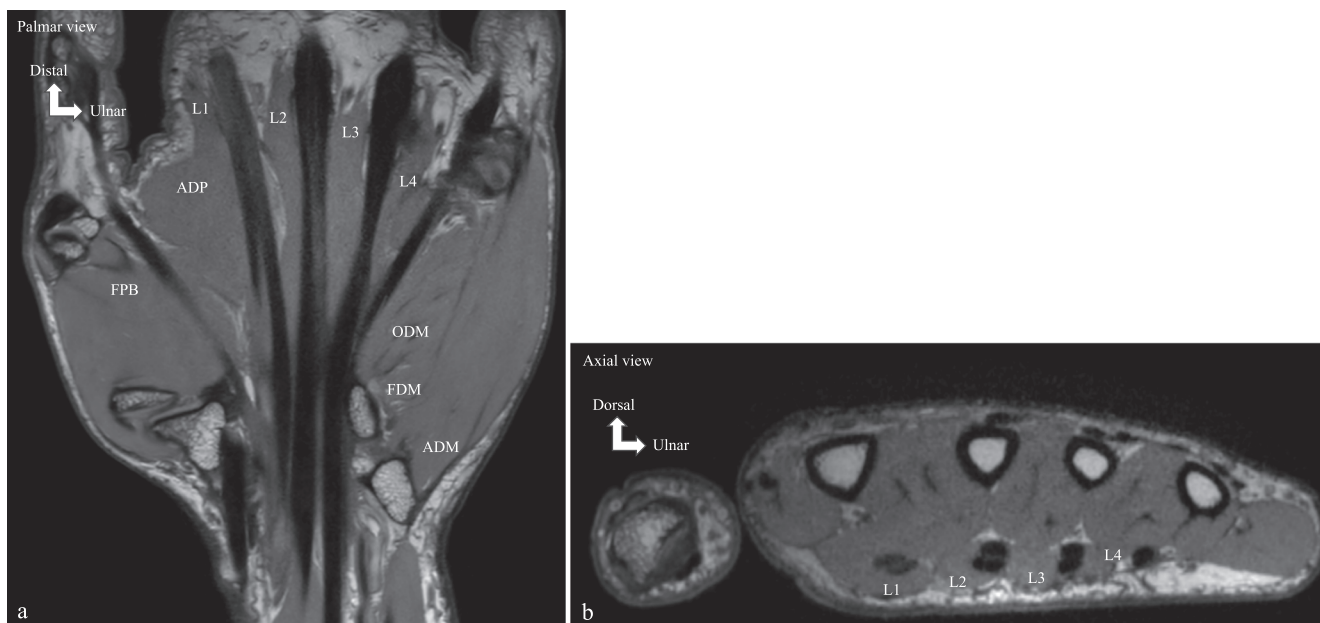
MRI showing the lumbrical muscles. Coronal (a) and axial (b) proton density (PD) MRI sequences. L1: First lumbrical muscle; L2: Second lumbrical muscle; L3: Third lumbrical muscle; L4: Fourth lumbrical muscle; FPB: Flexor pollicis brevis; ADP: Adductor pollicis; FDM: Flexor digiti minimi; ODM: Opponens digiti minimi; ADM: Abductor digiti minimi.
